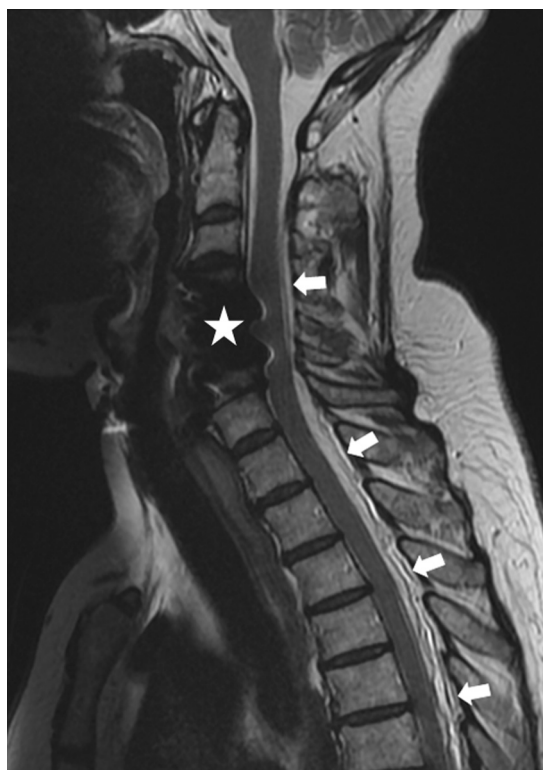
MRI of the cervical spine. T2-weighted sagittal section (TR/TE: 3427/102). Appearance of posterior epidural collection of fluid (arrow). Metal artefact of disc prostheses (star).
